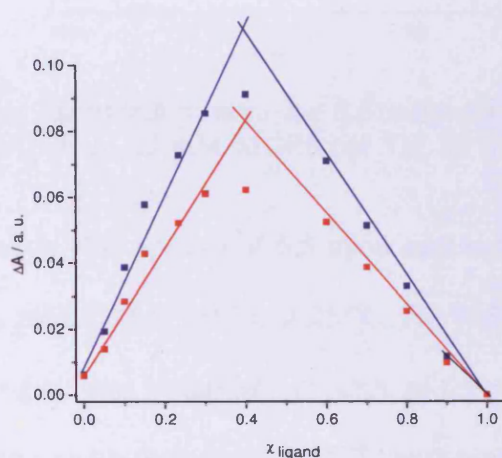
UV-visible Job plot for 5.5 interacting with CT-DNA, in buffer (25 mM MOPS, 50 mM NaCl and 1 mM EDTA), pH 7.0 at 25 °C. The changes in the absorbance at 410 (■) and 430 (■) nm wavelengths are plotted against the mole fraction of the ligand χ_{ligand}
